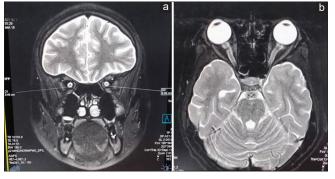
MRI brain with orbit showing normal ONSD (a) and no evidence of demyelination (b)
